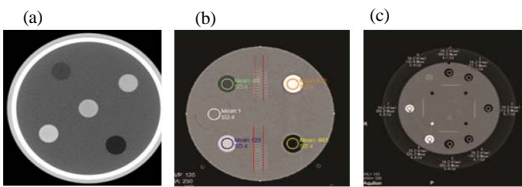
CT number: a) AAPM; b) ACR and c) Catphan
